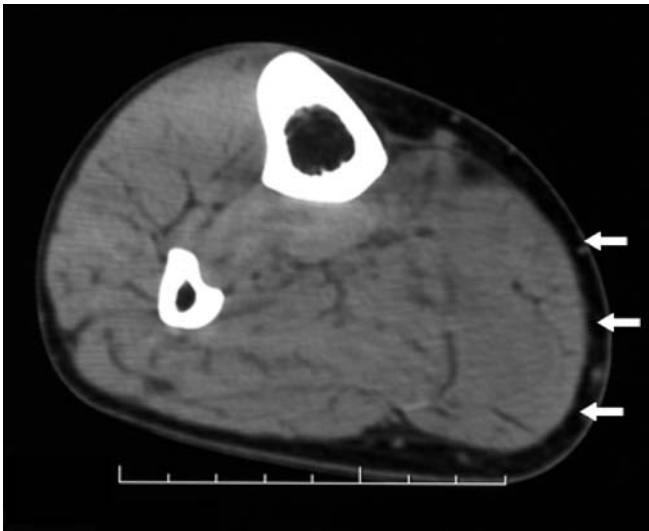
Computed tomography demonstrated an ill-defined mass (arrows) in the gastrocnemius muscle with density equivalent to that of the muscle
